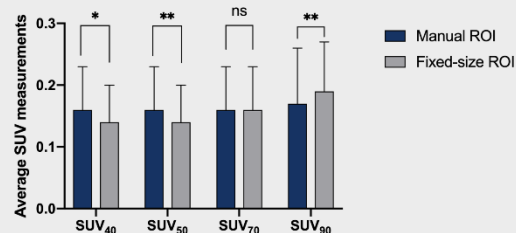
The average SUV measurements when 40%, 50%, 70%, and 90% SUV threshold values were applied to both control and disease models. Error bars represent the standard deviation. Asterisks indicate statistical significance.
